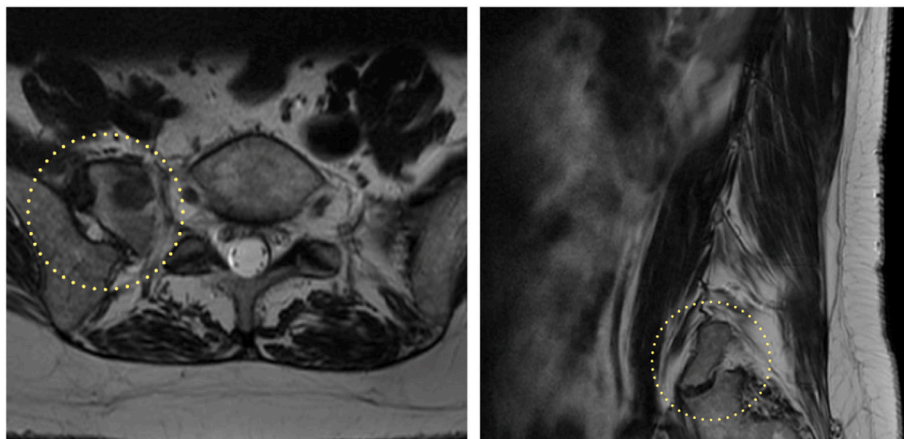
Axial and Sagittal T2 MRI sequence of right lumbar Bertolloti segment including pseudo-articulation.
